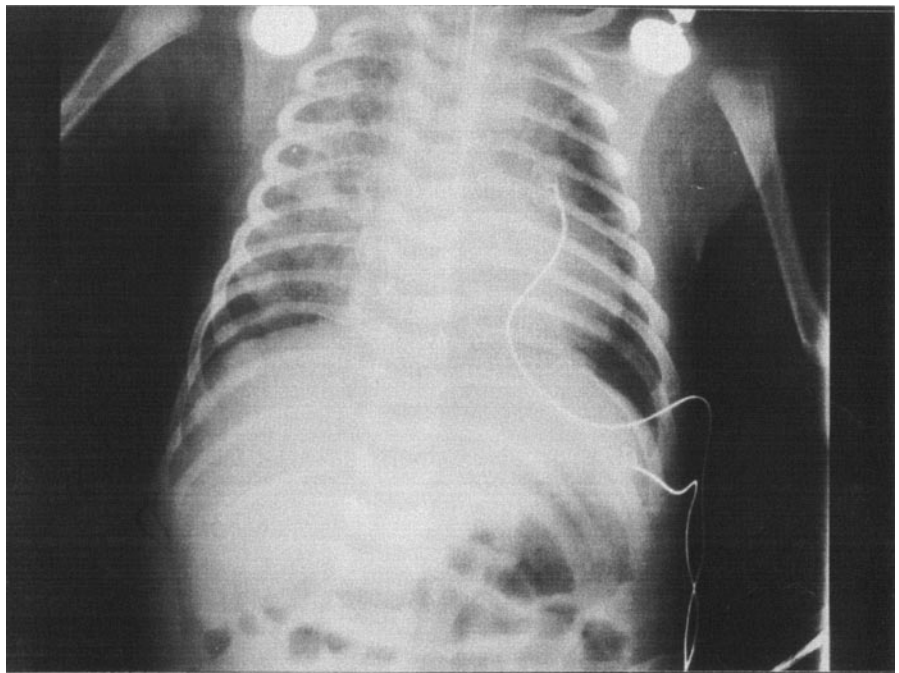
Follow-up chest radiograph showing resolution of the patchy infiltrates in the right lung.
